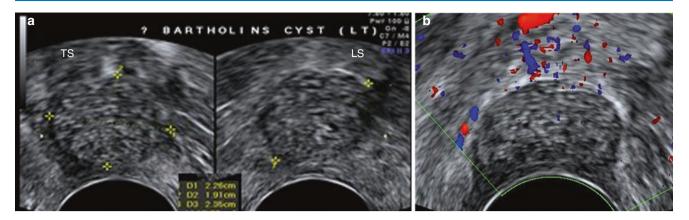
Bartholin gland cyst. (a) Hyperechoic scattered foci within. (b) No significant flow is seen on Doppler in the cyst walls
